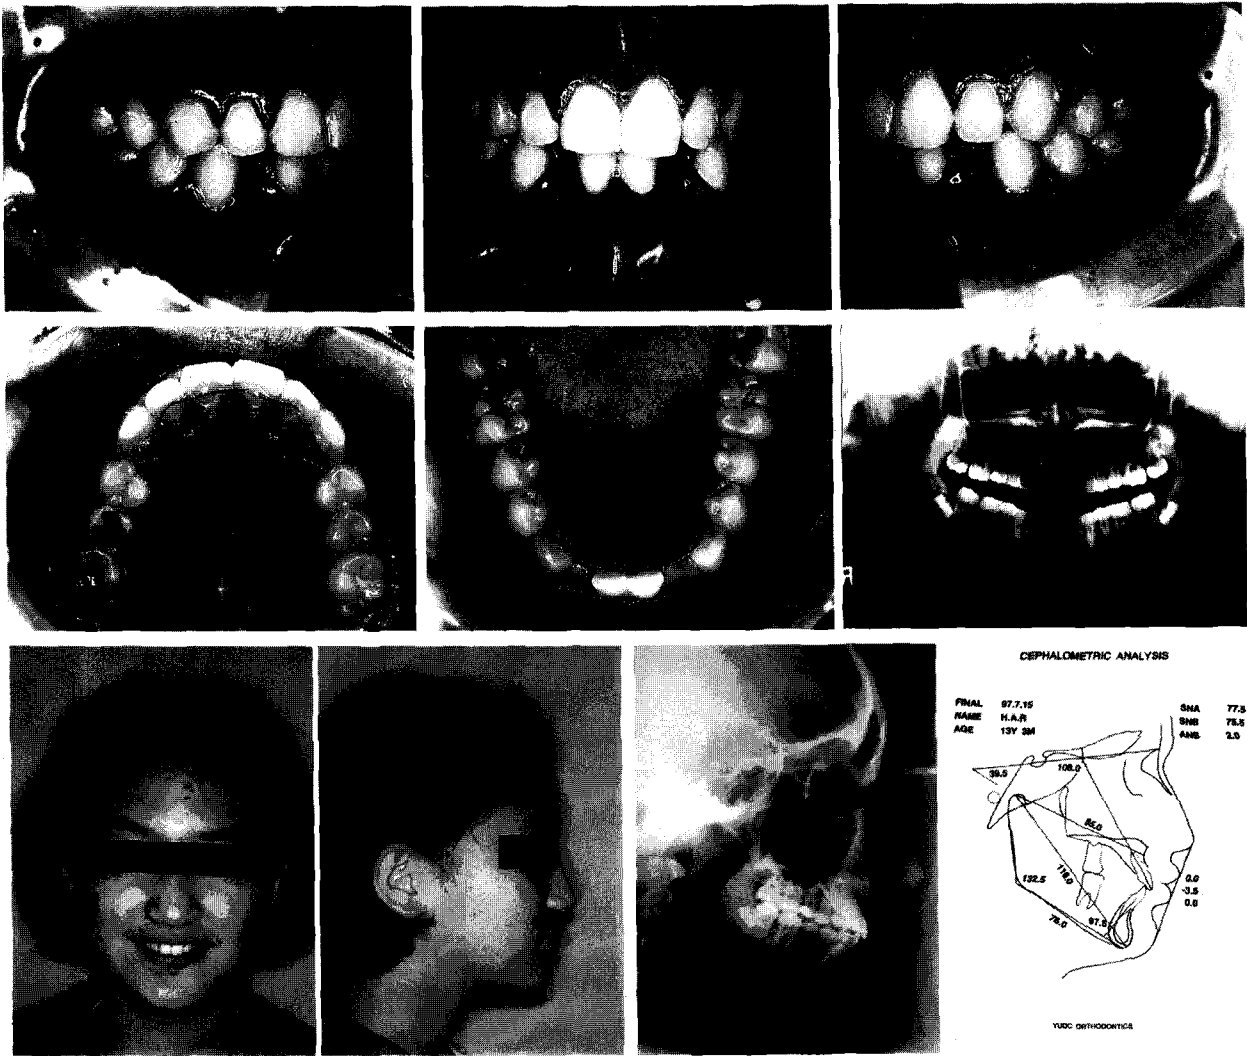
Post-treatment intraoral, extraoral photos and X-ray of case 2
